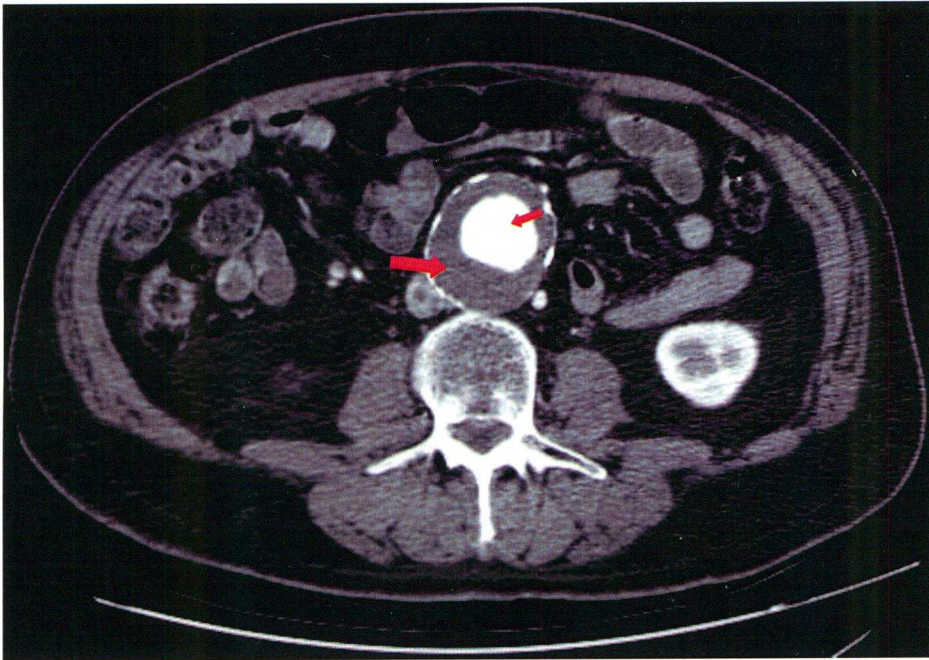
CT scan with contrast in the patent lumen (small arrow) of a typical AAA; thrombus (large arrow).
